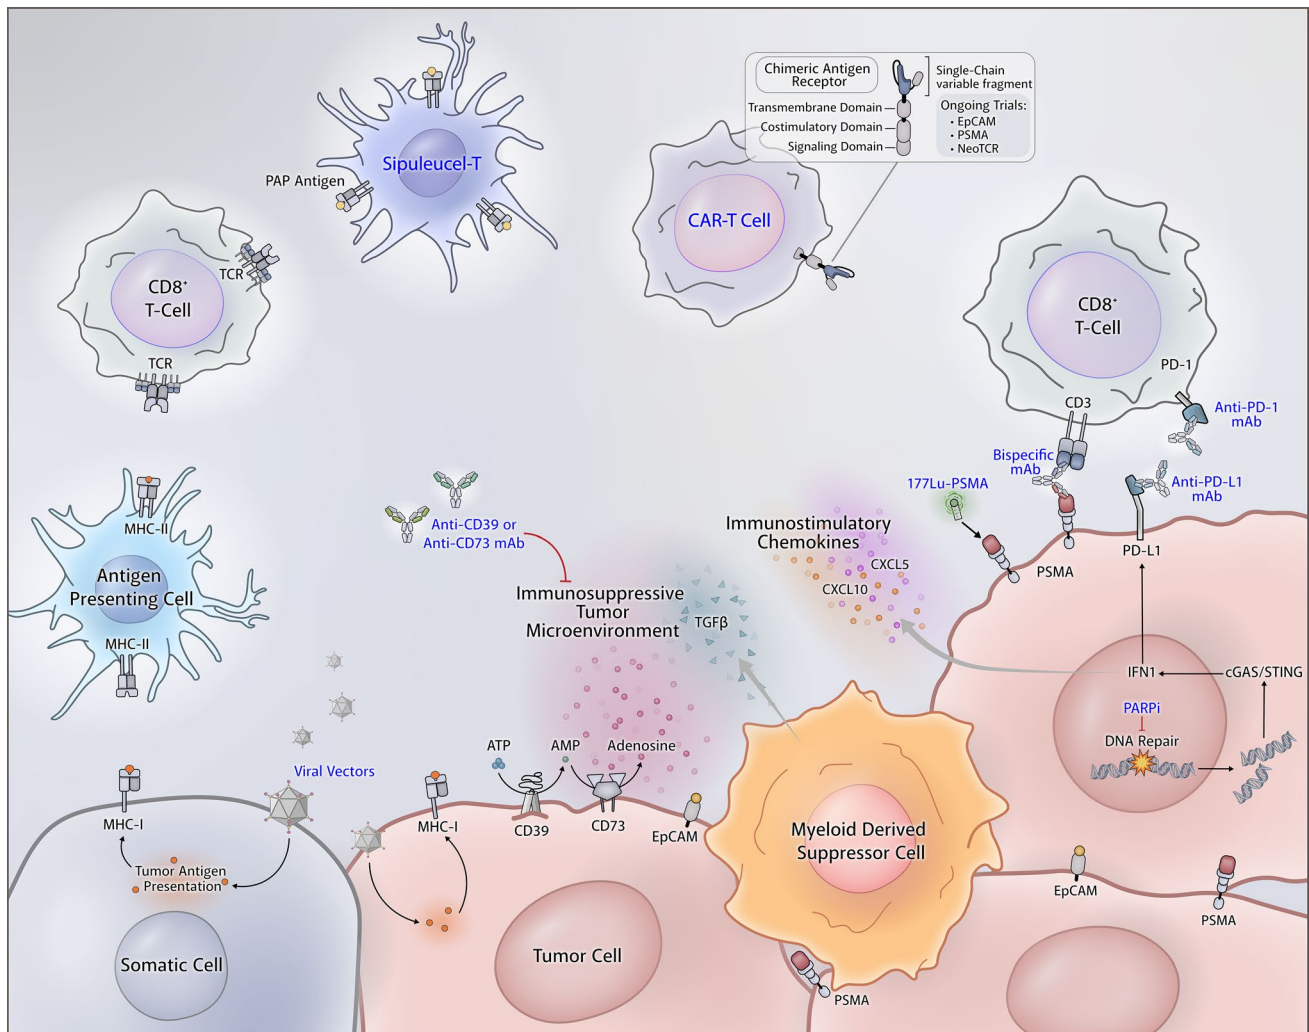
An overview of immune system pathways and targets in prostate cancer. Tumor specific-antigens from viral vectors (e.g. PROS-TVAC) are displayed on MHCs. Prostate cancer cells often express unique markers such as PSMA that are targetable with CAR-Ts. Patient-specific neoantigens are also potential targets with custom NeoTCRs. Other cell-mediated therapies, such as Sipuleucel-T, use prostate cancer-specific antigen-presenting cells displaying PAP to stimulate the immune system. Increased levels of extracellular adenosine, myeloid-derived suppressor cells, and immune checkpoints such as PD-1/PD-L1 prevent anti-tumor immunity but are also targetable with various monoclonal antibodies. Use of PARPi can cause the cells to not only increase chemokine production but also increase
